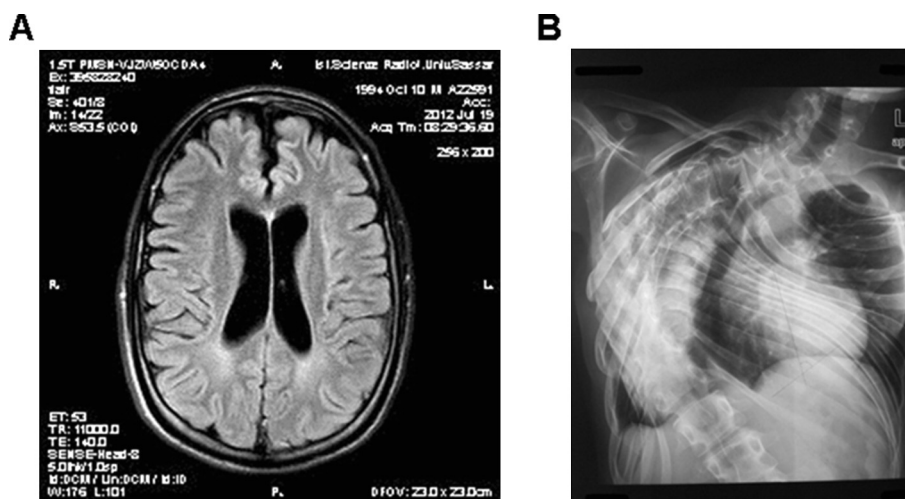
Imaging studies in a patient harboring a novel mutation in ALS2. A Brain MRI at age 17 years, FLAIR image: hyperintensities in posterior periventricular areas. B Spine X-ray of the dorsal tract: severe deformity due to right convex rotoscoliosis.
